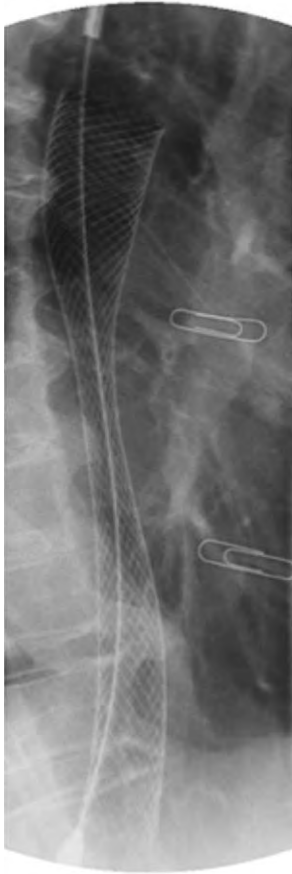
Radiograph of a deployed Flamingo stent crossing an esophageal tumor. The narrowing of the stent is at the area of the tumor. The paper clips are placed on the patient's skin and mark the proximal and distal extent of the tumor before stent deployment.
